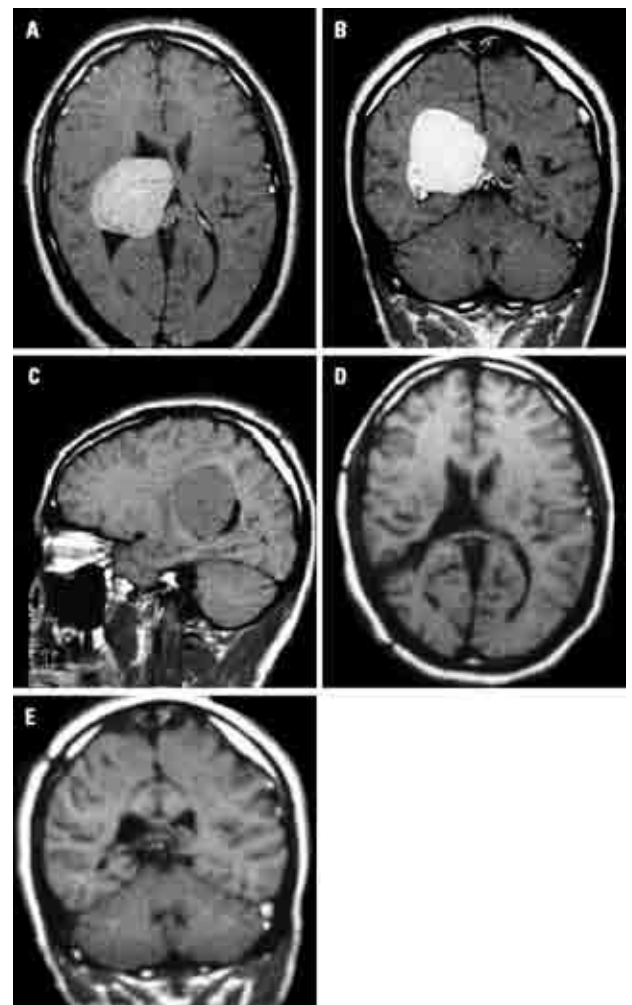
Case 1. A 30-year-old man developed moderate headache after mild head injury. He complained of forgetfulness for the last six months. [A, B and C] Pre-operative MRI. [D and E] Post-operative MRI after 6 months.
